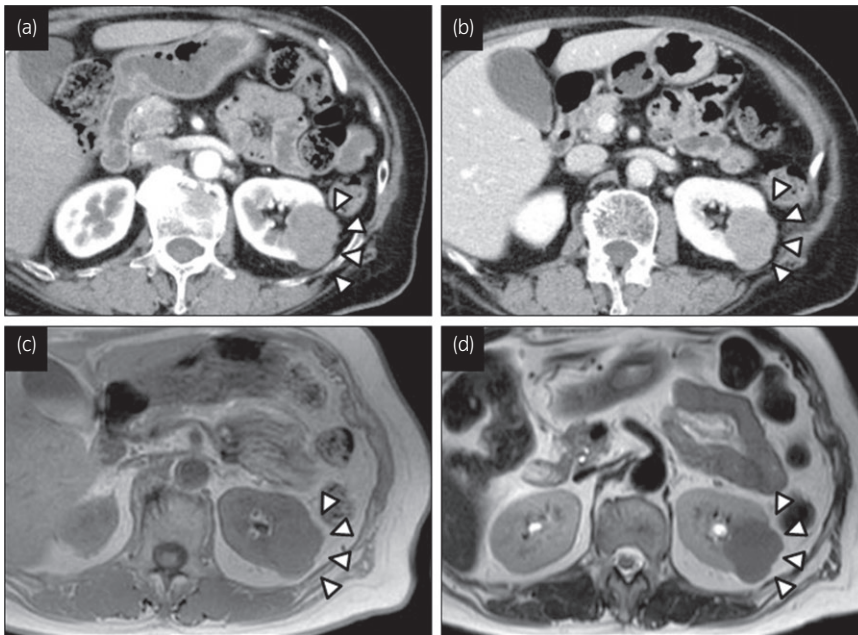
(a,b) Abdominal-enhanced CT, (c) T1-weighted MRI, and (d) T2-weighted MRI of a 38 mm sized renal tumor (white arrow).
